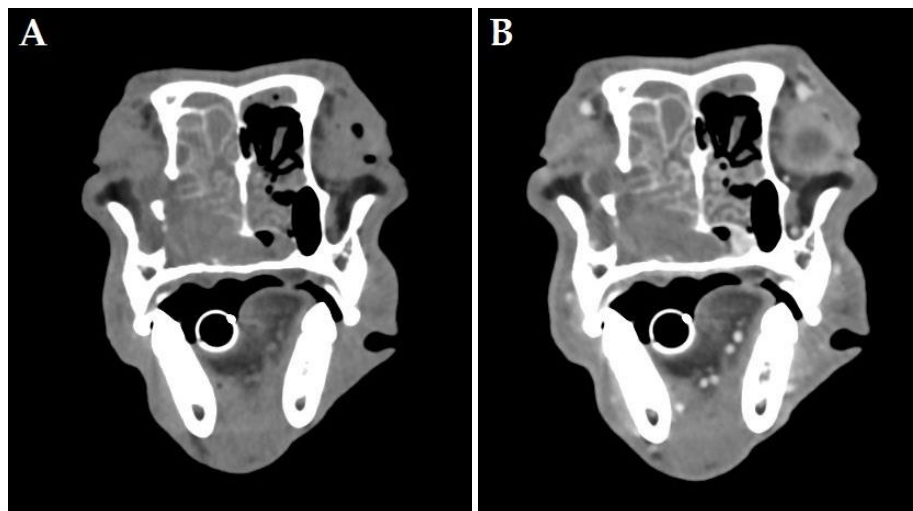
The helical CT images at the level of the infraorbital area. The soft tissue nasal mass revealed the concha calcification and there were bone lytic lesions at the nasal septum and nasal bone on the precontrast image (A). After contrast study, the mass was slightly enhanced. The capsule of left retrobulbar invaded mass could be detected (B).
